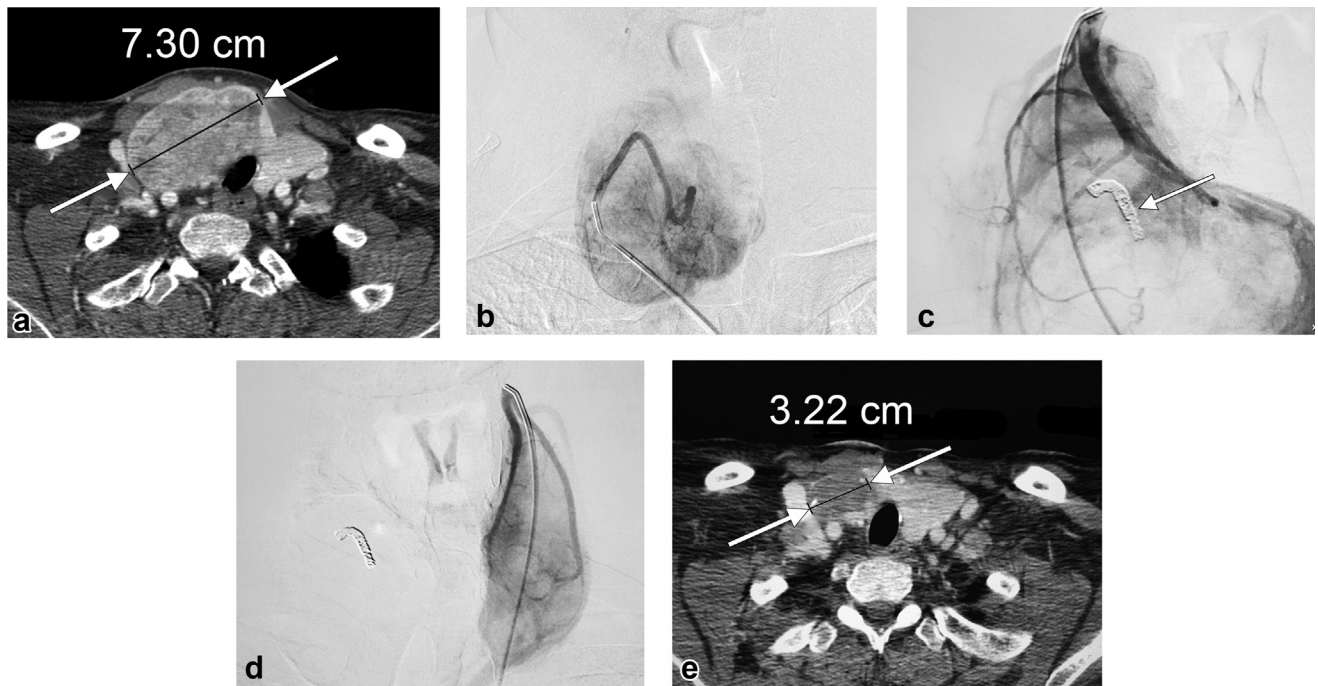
In a 45-year-old man with a large solitary cervical nodule in the right thyroid lobe, the axial image (a) shows the nodule (arrows) that measures $7.3 \times 7 \times 4.5$ cm (volume, 115 mL). The patient underwent particle and coil (arrow) embolization of the right inferior thyroid artery (the main supplier) and the right superior thyroid artery (b, c) while the arteries of the left lobe (d) were left intact. At 6 months, the follow-up axial computed tomography image (e) shows a marked shrinkage of the nodule in the right lobe measuring $4.5 \times 3.2 \times 2.1$ cm (volume, 15.1 mL; volume reduction, 87%) and compensatory hypertrophy of the healthy left lobe. The patient was asymptomatic and very satisfied with the cosmetic result.
